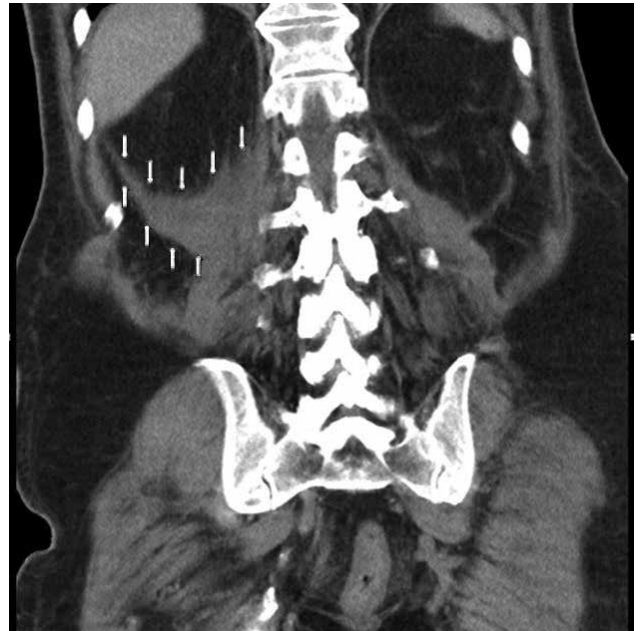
CT scan without contrast; coronal view; showing bleeding into the psoas muscle and the surrounding renal fascia
